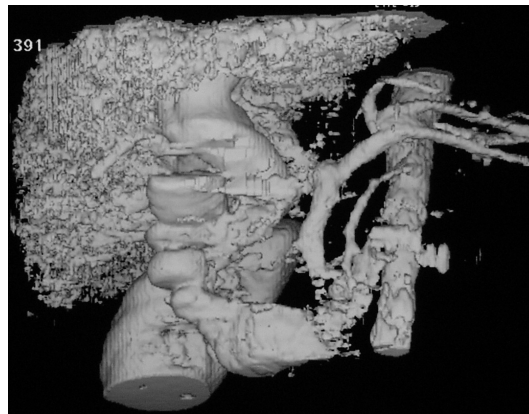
Example of CT reconstruction of the liver and bile tree
